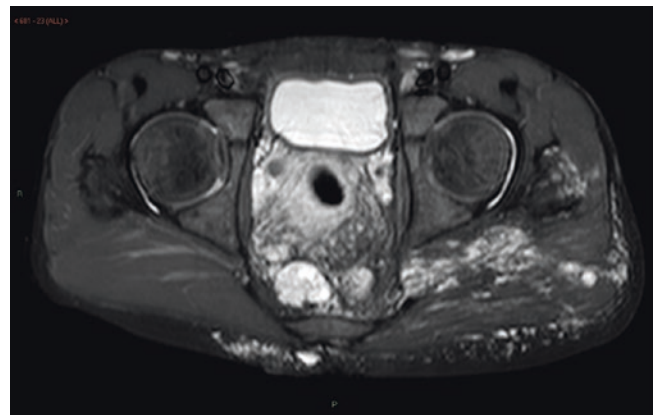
MRI of a boy with extensive lymphatic malformation shows high T2W/fluid signal extending throughout the pelvis, gluteal muscles on the left, and buttock soft tissues
